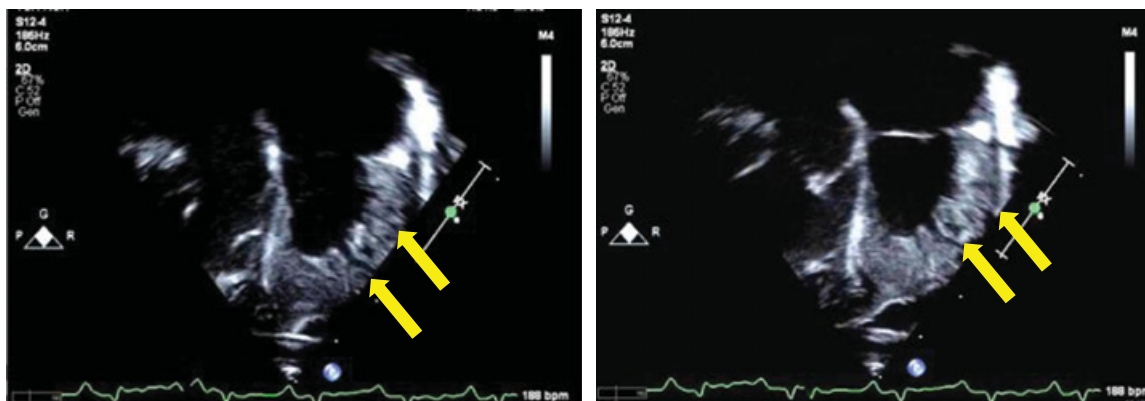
Transthoracic four-chamber view identifying deep trabeculations (yellow arrows) that are classic for LV noncompaction cardiomyopathy. Courtesy of Adam C. Adler, MD.
